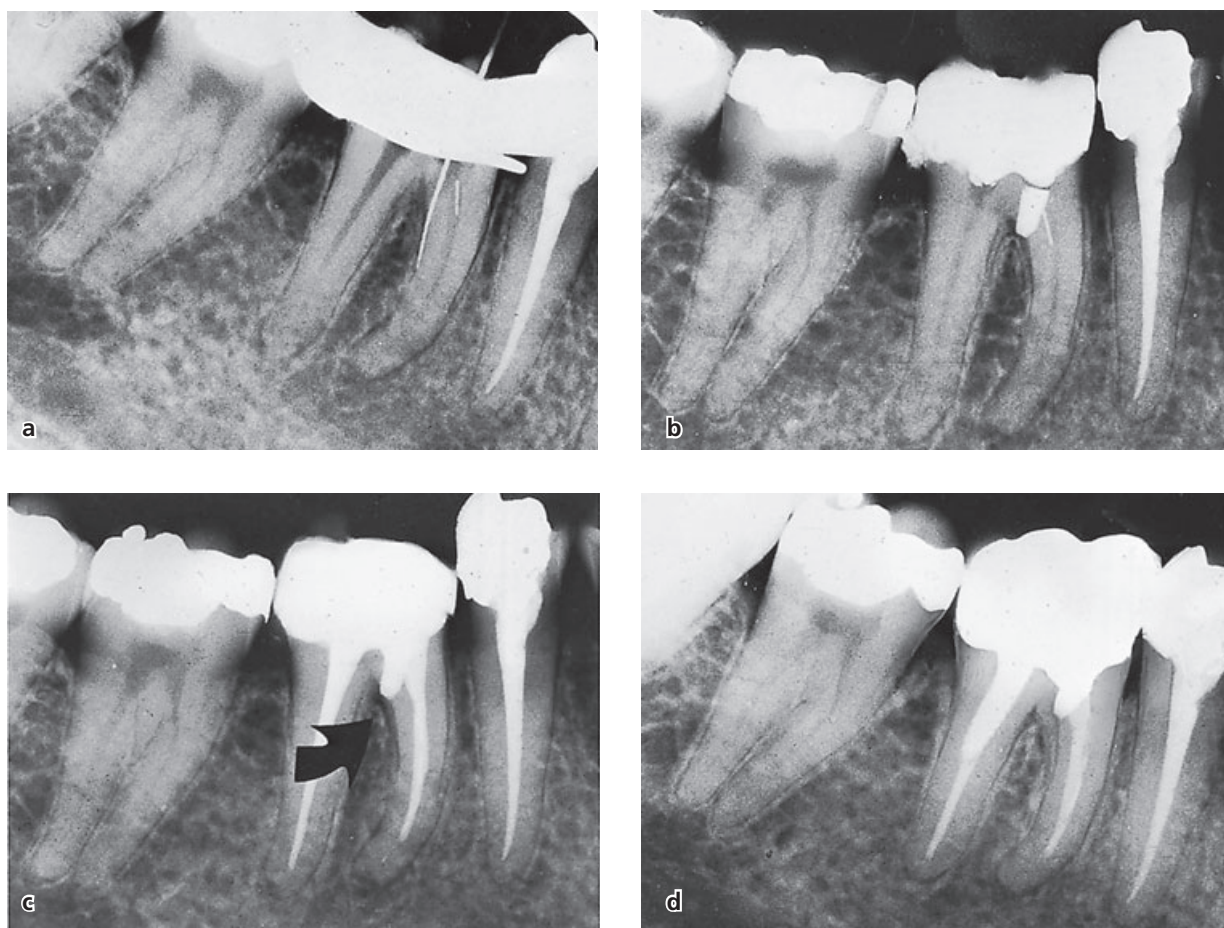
(a) Perforation of the pulpal floor of the mandibular first molar occurred in conjunction with a search for root canal openings. There is also a file fragment in one of the mesial canals. (b) The perforation was immediately sealed with gutta-percha. (c) In a radiograph taken 1 month after treatment a slight radiolucency is seen at the site of the perforation (arrow). (d) Follow-up after 2 years showed normal periodontal conditions both clinically and radiographically. Case kindly provided by Dr. Gunnar Heden.
